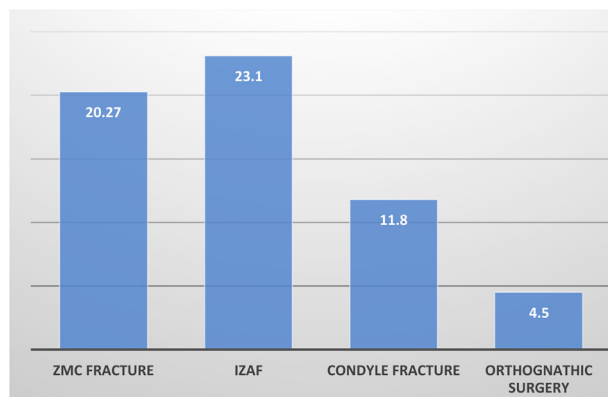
Percentage of patients undergoing immediate surgical correction after intraoperative CBCT, according to the clinical indication. (ZMC, zygomaticomaxillary complex; IZAF, isolated zygomatic arch fracture.)
